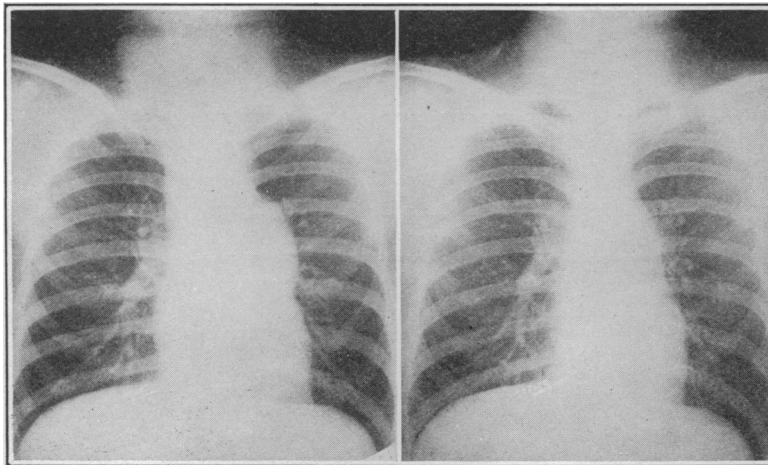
Roentgenogram made February 3, 1930, showing a large tumor, apparently originating in the mediastinal lymph nodes.
